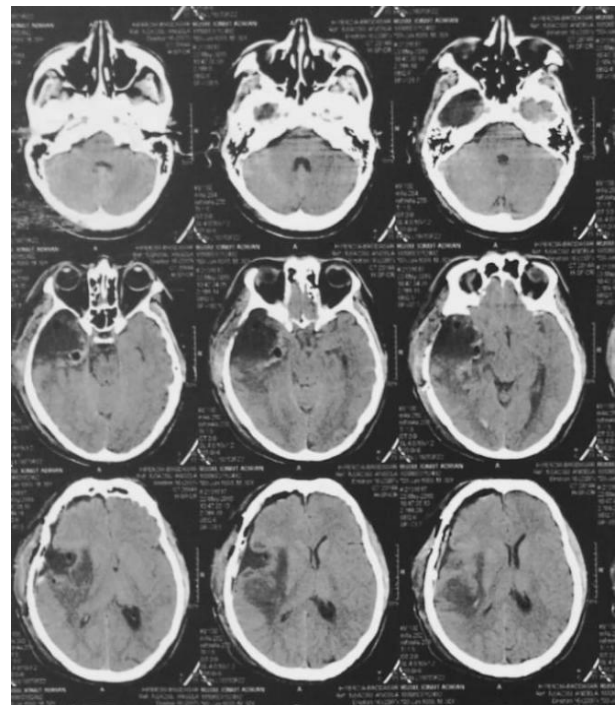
Postoperative CT scan showing the resection cavity
